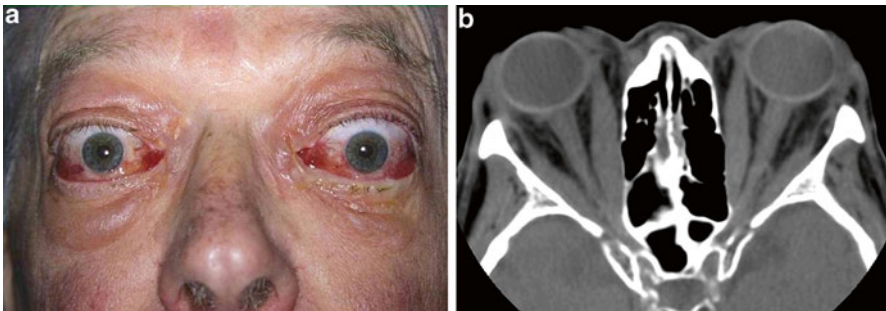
(a) A 73-year-old male with progressive, rapid onset of severe inflammatory features with restricted ocular movements. (b) Axial CT Scan demonstrates enlargement of horizontal recti muscles bilaterally, corresponding with areas of redness and swelling on the bulbar conjunctiva. There is probable crowding of the optic nerve at the apex
